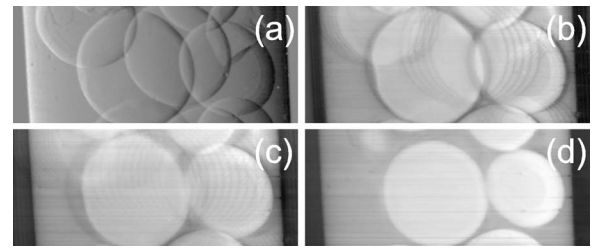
(a) One example of the pure refraction contrast: the intensity is proportional to the deflection angle with the middle-gray corresponding to the zero deflection. TS reconstruction from (b) 5 and (c) 11 projections. (d) CT reconstruction from 1800 projections.
